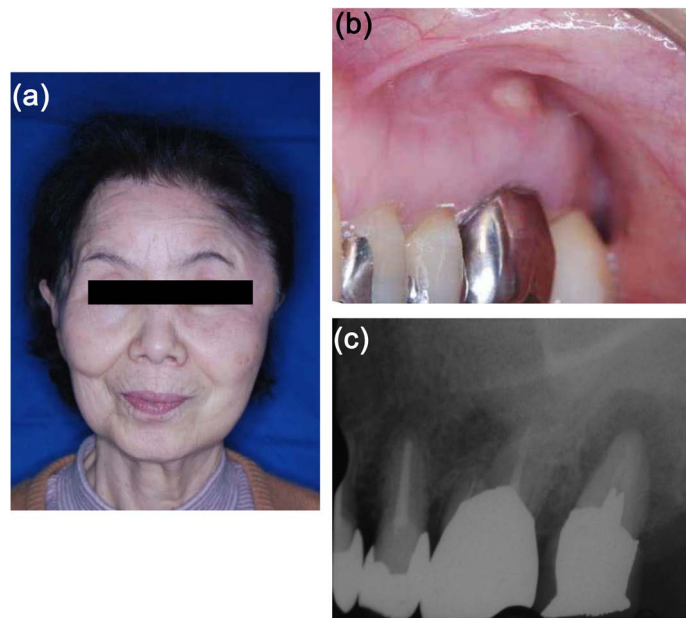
(a) Extra-oral finding at the first visit. (b) Intra-oral findings at the first visit. (c) Dental X-ray confirmed a transmission image at apical of the upper left side of the second molar.
